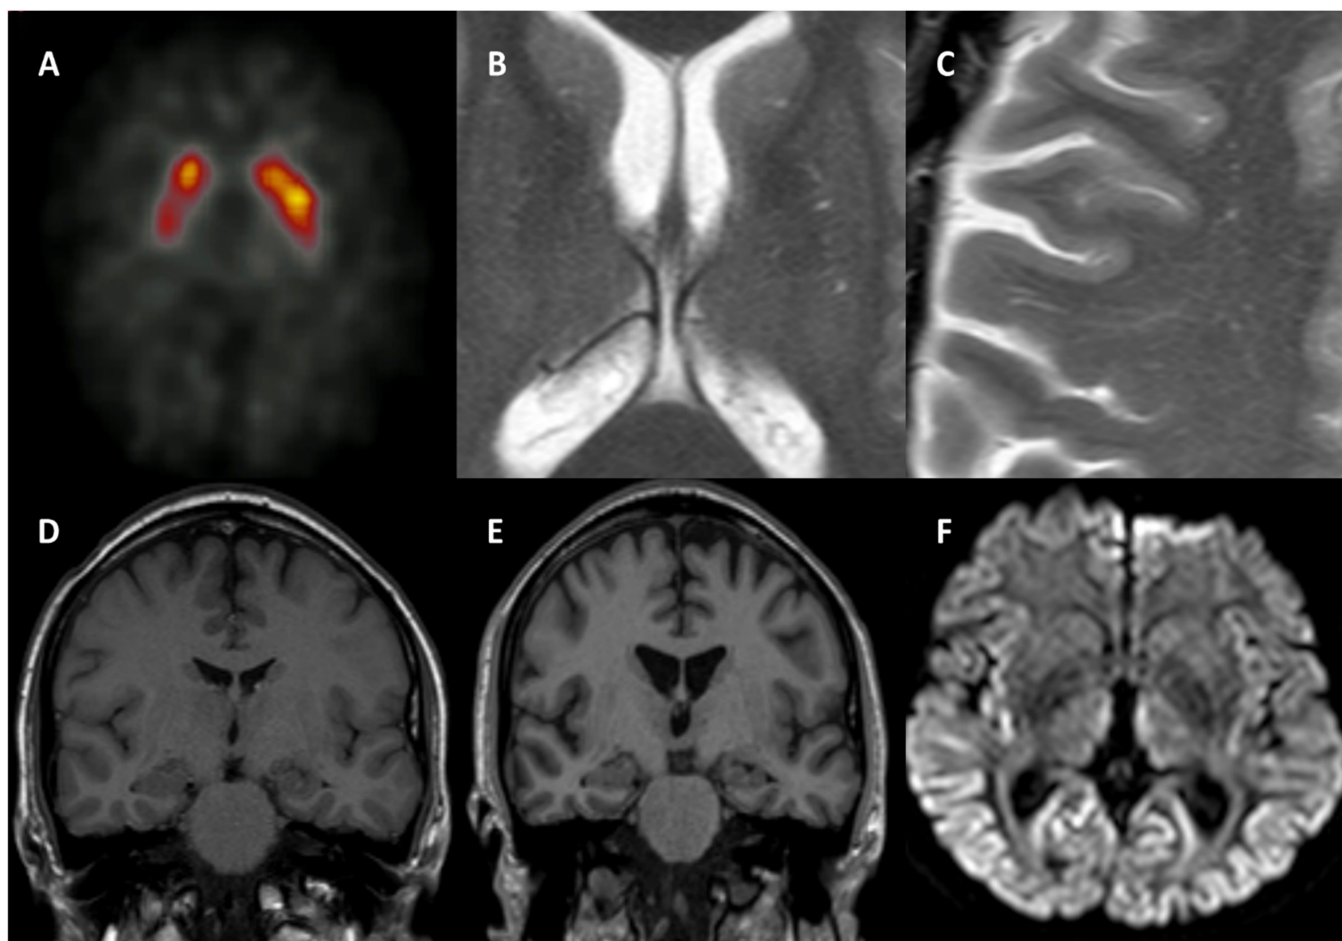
Neuroimaging findings. (A) DaTscan of basal ganglia 1 year after onset showing heterogeneous but atypical reduced uptake. (B) T2-weighted MRI showing hyperintensities in the basal ganglia (C) T2-weighted MRI showing hyperintensities in cerebral white matter at 1 year before onset. (D) Coronal MRI from 1 year before onset (background of chronic headaches). (E) Coronal MRI from 1 year after onset showing significant cortical and hippocampal atrophy and ventricular dilatation. (F) Diffusion-weighted MRI from 1 year after onset showing hyperintense cortical ribboning in the frontal, parietal and occipital cortices, insula and thalamus.
